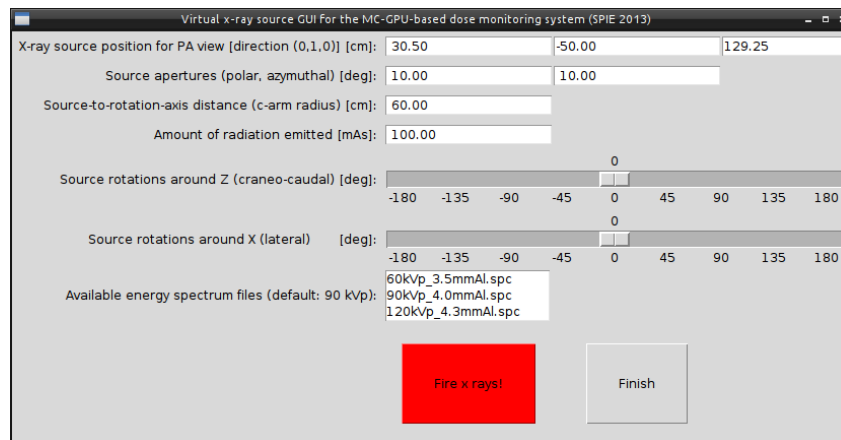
Graphical user interface of the virtual x-ray source.
